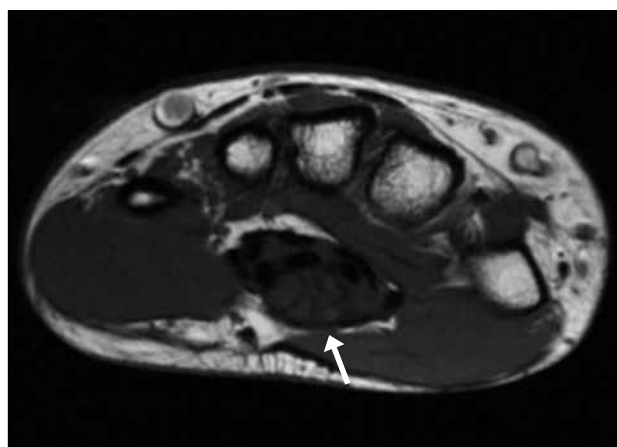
Same patient as in Figure 14. Axial T1 magnetic resonance image of the wrist showing characteristic coaxial appearance of the thickened median nerve (arrow) at the carpal tunnel.
